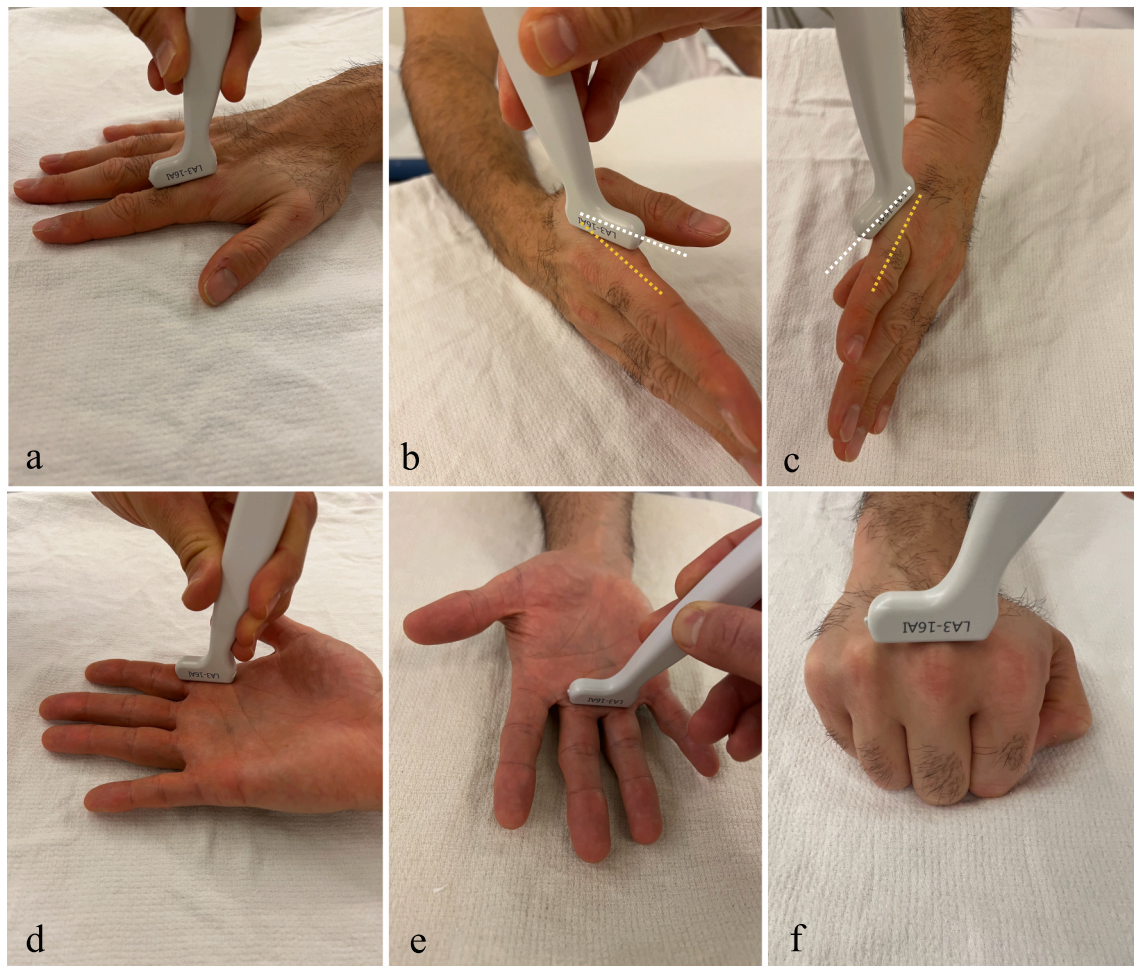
Ultrasound technique for evaluating the MCPJ of the long fingers. *Longitudinal dorsal US of the index MCPJ (a):* The probe is positioned along the longitudinal axis of the MCPJ with the finger in extension. *US of the radial collateral ligament of the index MCPJ (b):* The radial collateral ligament originates dorsally from the metacarpal and inserts distally and palmarly onto the P1. The US probe should follow this dorsopalmar oblique path (white line) rather than the radial longitudinal axis of the MCPJ (orange line). The ligament is examined in the coronal plane along the radial aspect of the MCPJ, where it appears as a continuous fibrillar structure. *US of the lateral collateral ligament of the index MCPJ (c):* The lateral collateral ligament originates dorsally from the metacarpal and inserts distally and palmarly onto P1. The probe must be aligned along the dorsopalmar oblique path (white line) and not parallel to the ulnar longitudinal axis of the MCPJ (orange line). The ligament is assessed in the coronal plane along the ulnar side of the MCPJ. *Palmar US of the index MCPJ (d):* The probe is placed along the longitudinal axis of the MCPJ with the finger in extension. *Palmar US of the intermetacarpal space (e):* The probe is positioned transversely (axial view) across the intermetacarpal space with the fingers extended. *Dorsal US of the MCPJ (f):* The probe is positioned in the axial plane over the dorsal surface of the MCPJ. The extensor tendons should be assessed dynamically during finger flexion and with the hand in a clenched fist position.
